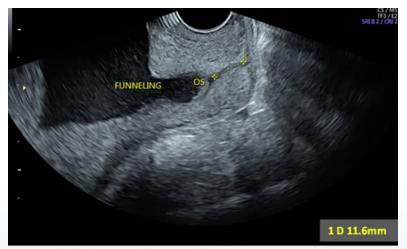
A short cervix with funnelling is seen during a transvaginal Ultrasound
